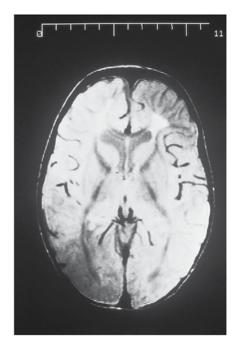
MRI of the brain of the patient in Figures 46.3 and 46.4 at 2.5 years revealed increased signal intensity in the frontal white matter. (Reprinted with permission from the Journal of Inherited Metabolic Disease [9].)
